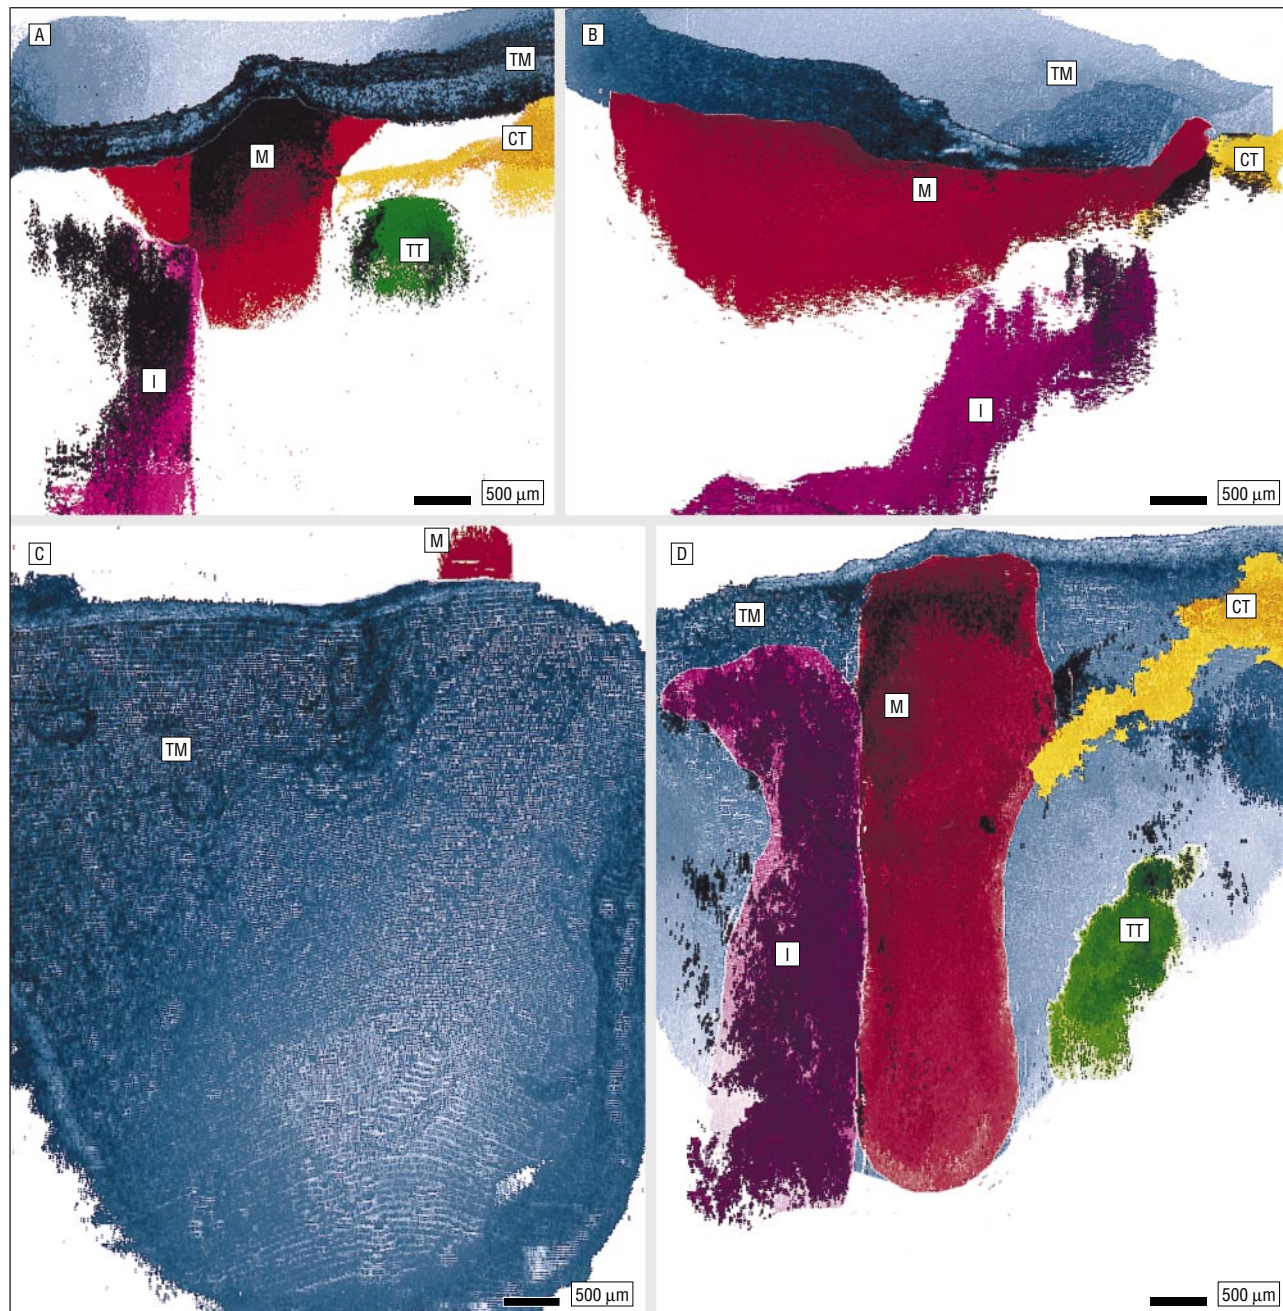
Volume reconstruction of a data set of ex vivo optical coherence tomographic images of the human middle ear. The 3-dimensional nature of the structures identified in Figure 4 are visible from different view angles: superior (A), coronal (B), lateral (C), and medial (D). The tympanic membrane (TM), the manubrium of the malleus (M), the long process of incus (I), the chorda tympani nerve (CT), and the tendon of the tensor tympani muscle (TT) can be identified (volume size, $5 \times 5 \times 5$ mm; 142 cross-sectional images; resolution, $15 \mu\text{m}$).
